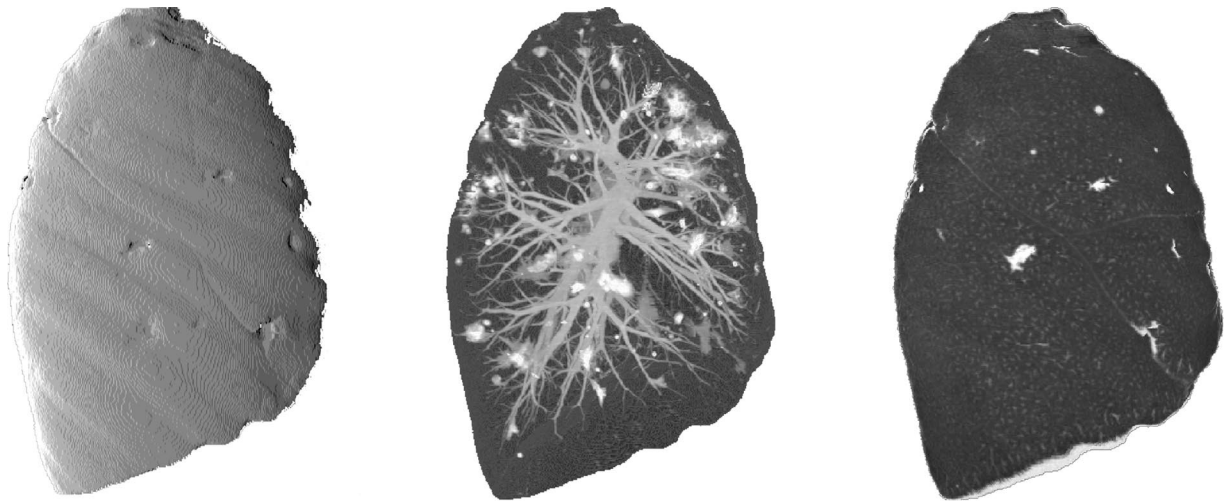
Novel visualization techniques for lung CT data. Left: Filtered distance map of the right lung. Center: Maximum intensity projection view of the right lung shows multiple calcified metastases. Right: Image of reformatted data close to the surface of the right lung.
